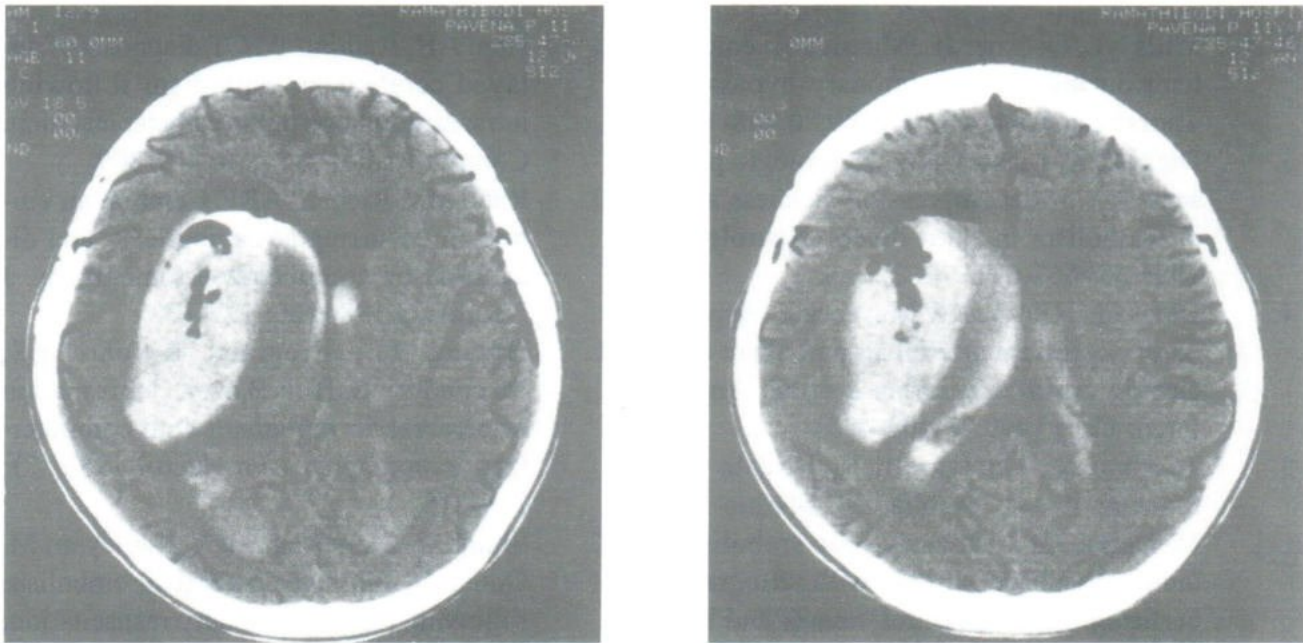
NCE axial CT scan of the brain showed a large right cerebral hemispheric hematoma, leaking to lateral ventricle. Note the air in the hematoma, probably came from the ruptured artery. (Air in the convexity arteries of both sides were also shown.)
